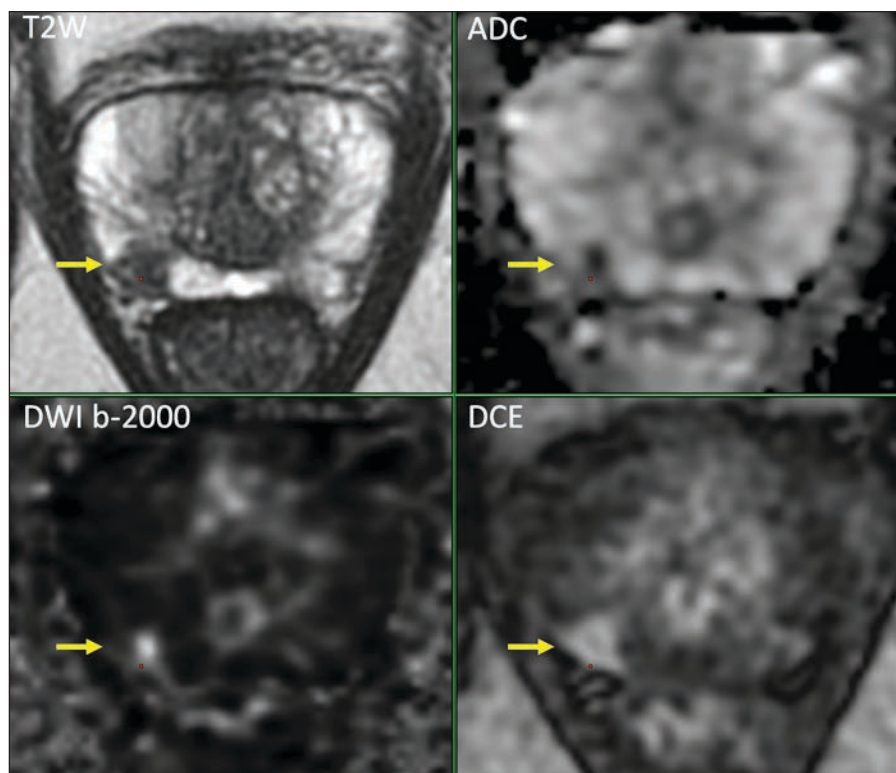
DCE-MRI adds value in smaller lesions with PI-RADS 4 scores in non-contrast MRI. 68 year-old man, cT1, PSA 8.6 ng/ml, PVMri 34 ml, PSAD 0.25 ng/ml², primary diagnosis. Suspected lesion of 6 mm right peripheral zone with PI-RADS score 4 (T2W:4, DWI/ADC:4, DCE: +). This wedge-shaped lesion on T2W showed microfocal marked diffusion restriction b-2000 and ADC. Despite wedge-shaped characteristics, as a benign feature, lesional focal enhancement (DCE+) supported the DWI/ADC suspicion, and increased reader confidence. Five MRI-directed fusion biopsies (including penumbra) revealed Gleason score 3+4=7 (ISUP grade 2) with cribriform / intraductal growth (reduced prognostic prostate cancer), in all three biopsies.
